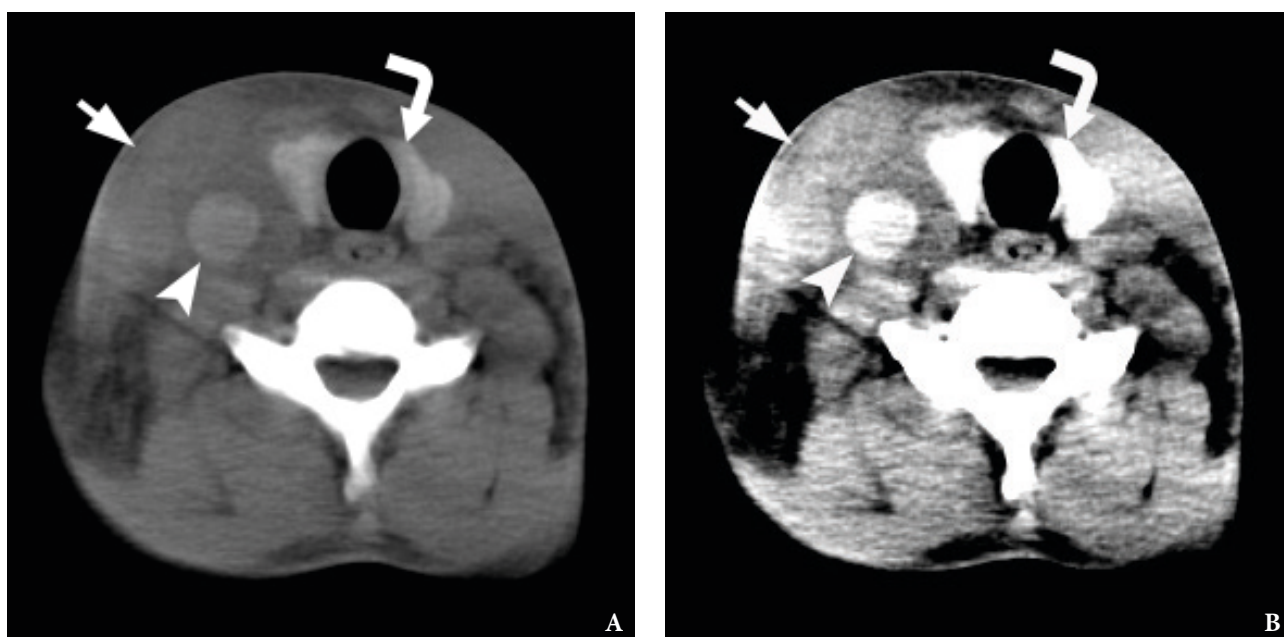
Comparison of “head neck window” (A) and “brain window” (B) upon verification of IJV thrombosis (*arrowhead*) using non-contrast multidetector CT. A and B are the same axial scan at the level of thyroid gland (*curved arrow*). *Arrow* – a swelled right sternocleidomastoid muscle.
